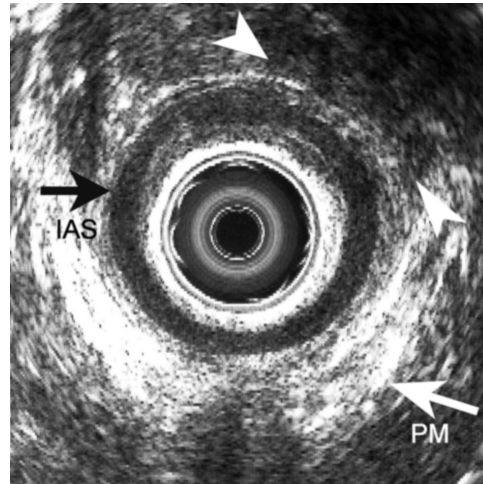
Transverse endoanal ultrasonography obtained from the same patient as in Figure 3a showing an EAS defect at upper edge (arrow heads) at the proximal anal canal. This finding was confirmed at anal sphincter repair, revealing an anterior EAS defect. The top of the figure is anterior. IAS = internal anal sphincter, PM = lower edge puborectal muscle
